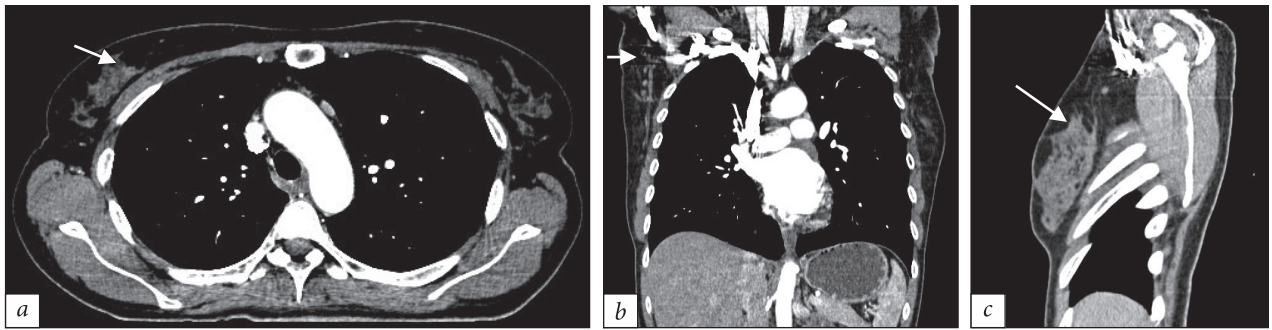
Computed tomography scan of the chest in axial (a), coronal (b), and sagittal (c) reconstructions at the level of the upper quadrants of the right breast in a woman with breast cancer after neoadjuvant chemotherapy. A small lesion measuring $11 \times 8 \times 10$ mm with an irregular shape, low-intensity contrast enhancement, indistinct margins, and a homogeneous internal structure is visualized
